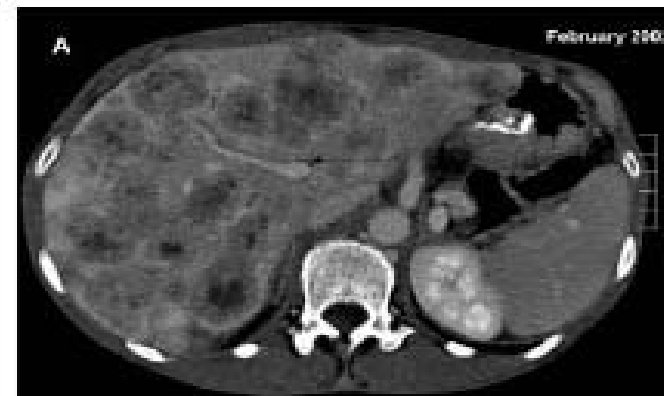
CT scans of representative patient with PD-NECs undergoing cisplatin and L-leucovorin/fluorouracil combination chemotherapy. Panel A shows pre-treatment assessment; panels B and C show objective response of multiple liver metastases at 3 and 12 months, respectively.
